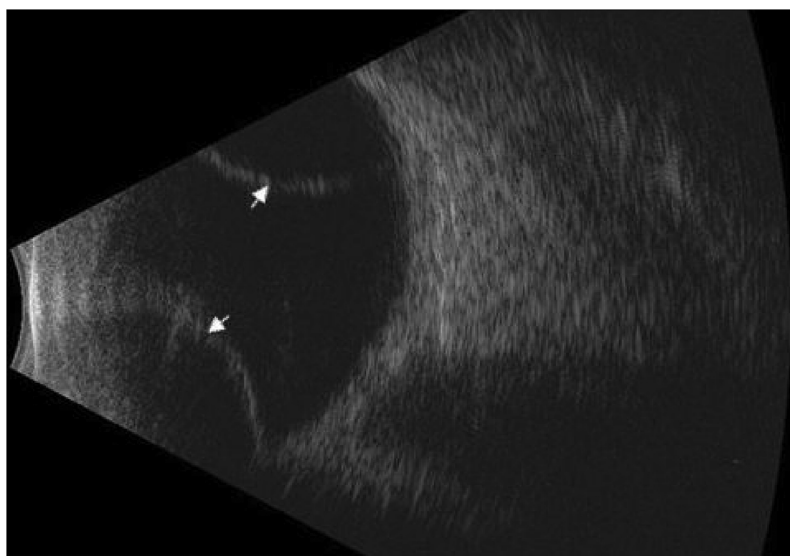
An axial ultrasound scan of a 30 year old male, shows the features of CD (arrows).
